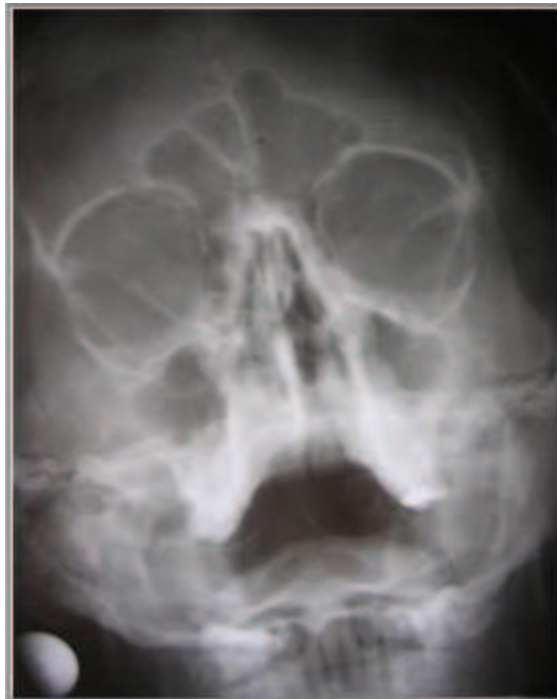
Appearance of Frontal Sinus in an x-ray
